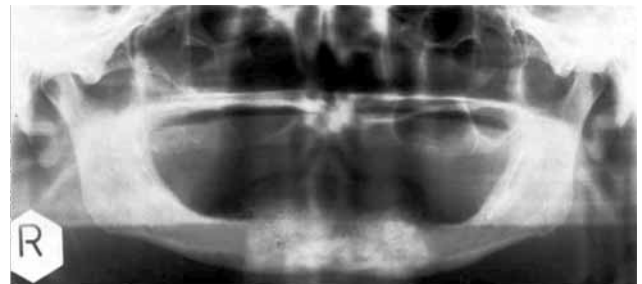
Panoramic radiograph of the patient after local increase of density of the edentulous mandible
